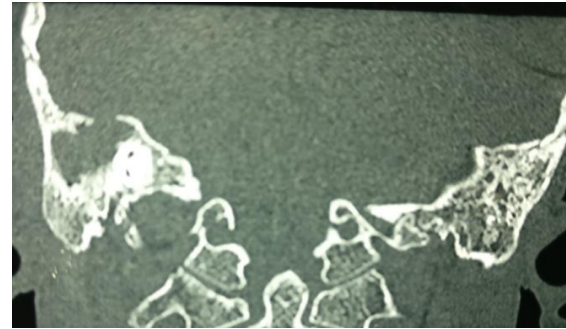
HRCT temporal bone coronal section showing right ear tegmen tympani erosion.
